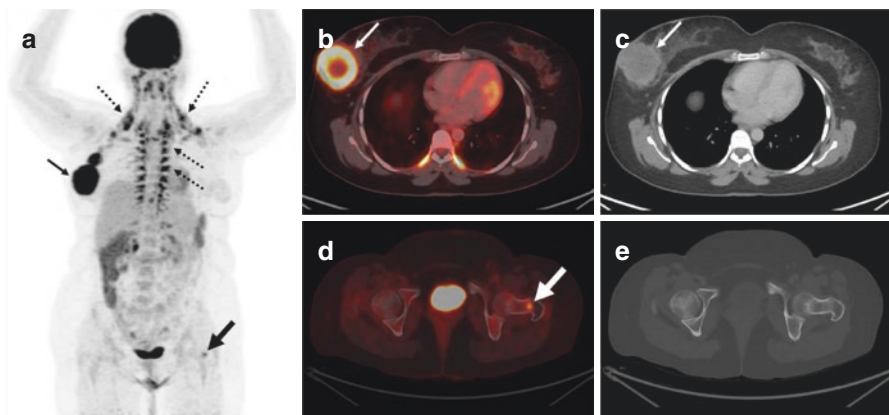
A 38 year-old-woman with newly diagnosed right breast carcinoma (IDC, grade II) – staging done with CT Chest, abdomen and pelvis showed a right breast mass with multiple matted right axillary lymph nodes, no distant metastases; whole body bone scan – normal study. ^{18}F -FDG PET/CT was performed for initial staging. Maximum intensity projection image (a) shows physiologic brown fat uptake of ^{18}F -FDG in the bilateral cervical, supraclavicular and para-vertebral regions (dotted arrows). Trans-axial fused PET/CT (b) and CT (c) images show the tracer avid, necrotic right breast primary mass (thin-arrow) with a tracer avid marrow lesion in the neck of the left femur (d; thick-arrow), that was inconspicuous on CT (e) and not detected on prior imaging. The patient was up-staged to AJCC stage IV in view of distant metastasis
